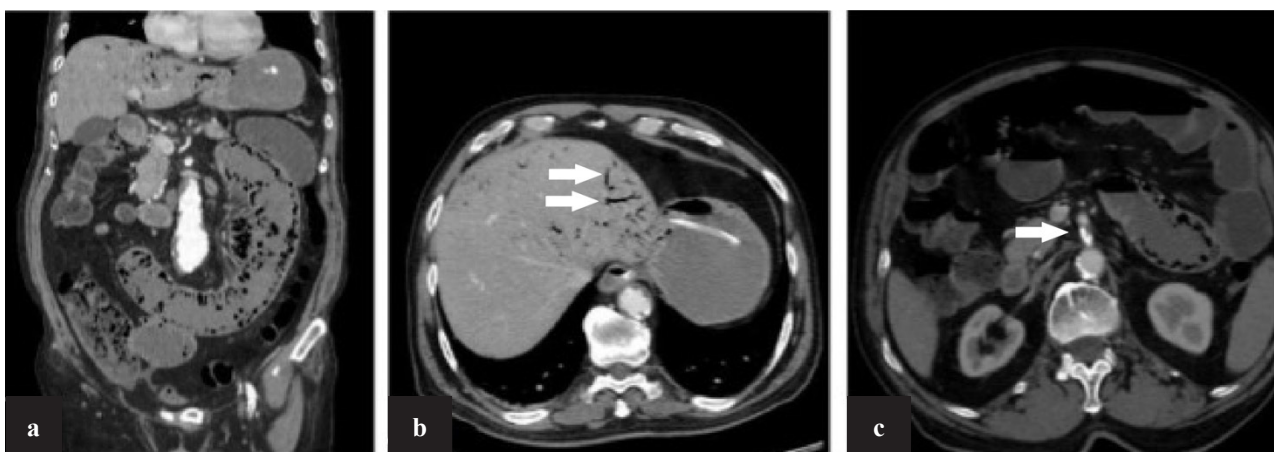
CT of the abdomen with intravenous contrast – 1a. Oedematous bowel loops with presence of intramural air for at least 100 cm of jejunum; 1b. Presence of air in the portal system (white arrows); 1c. Atherosclerosis of the origin of SMA (white arrow)
